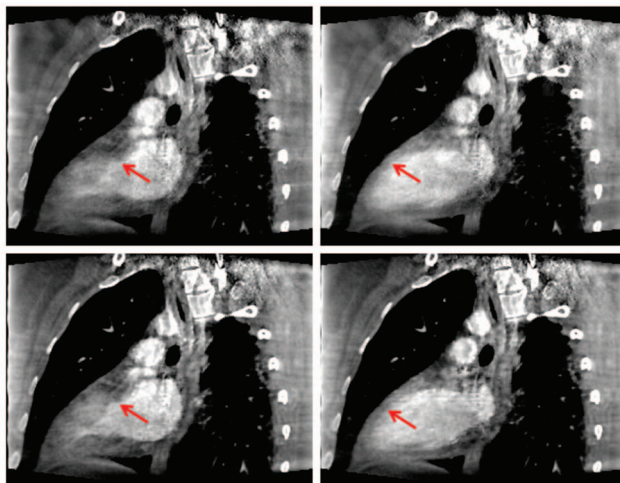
Long axis cut of the left ventricle of the end systole (left) and end diastole (right) frames of 4D cone-beam CT images reconstructed with PICCS [34] (top) and ROOSTER (bottom) from projections acquired on a C-arm cone-beam CT scanner. Figure adapted from [J51].
